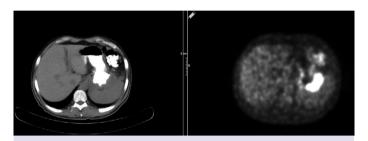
Image of positron emission tomography computed tomography, regression after neoadjuvant therapy locally advanced gastric hepatoid carcinoma (SUDmax: 12.7).
